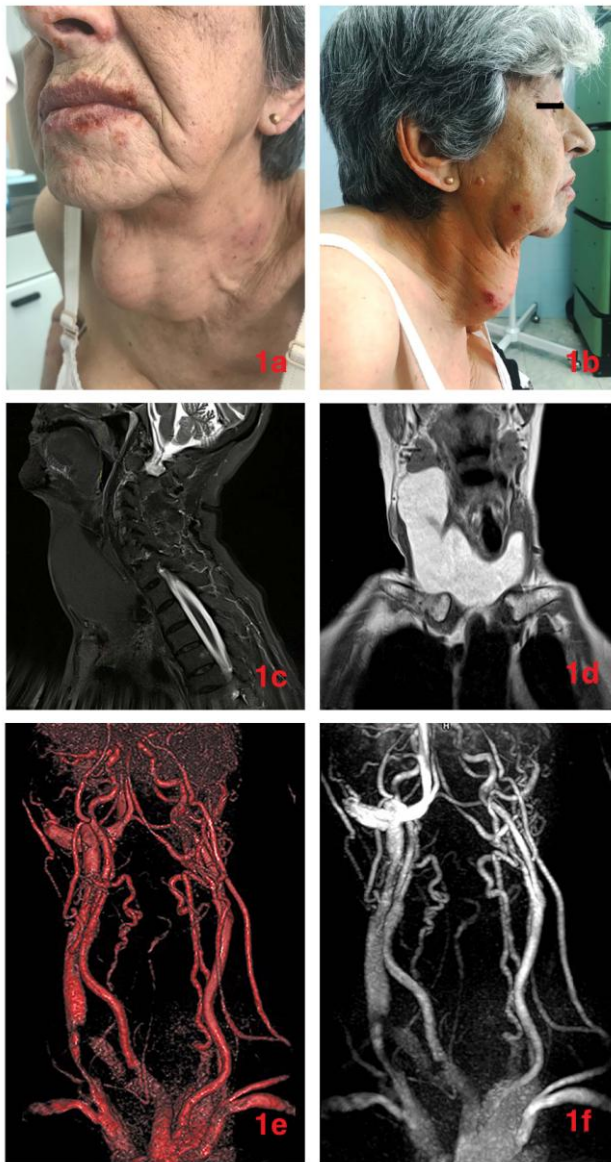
a, b) At the dermatological examination (front and sideways of the neck)-an oval lesion with the soft-elastic constellation. Clinical image of disseminated nummular partially pyodermic patches; c, d) Pre-surgical magnetic resonance imaging of the neck confirmed the presence of a lesion of the anterior cervical space. Tumour burdens from horizontal and vertical view; e, f) MRI contrasting blood system in the neck
